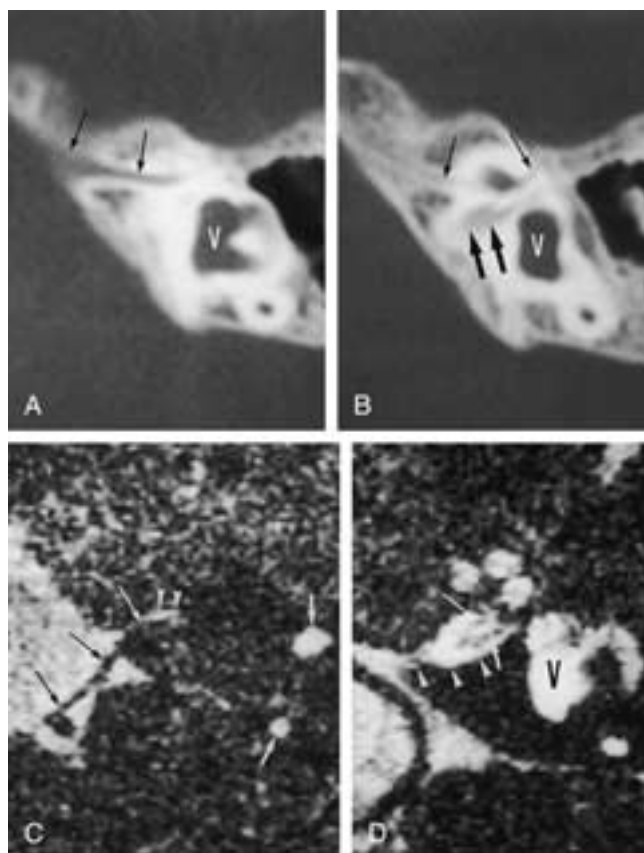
Facial nerve running in a separate canal parallel to the IAC. A and B, Axial CT image made above the left cochlea (A) and at the level of the upper part of the left cochlea and through the IAC (B). A, A separate canal for the facial nerve can be seen high and anteriorly in the left temporal bone (long black arrows). V, vestibule. B, The facial nerve canal can be followed posterior to the upper part of the cochlea (long black arrows). The IAC can now also be seen (large black arrows). V, vestibule. C and D, Axial 0.7 mm thick 3DFT-CISS images made at the level of the superior semicircular duct (C) and IAC (D). C, In the cerebellopontine angle, the facial nerve can be found in a high and anterior position (long black arrows) and continues its course in a separate facial nerve canal (long white arrow). Fluid in the labyrinthine segment of the facial nerve canal (white arrowheads) and fluid in the branches of the superior semicircular duct (small white arrows). D, The cochlear branch (long white arrow) and inferior vestibular branch (small white arrow) of the eighth nerve can be seen in the CSF-filled IAC (white arrowheads). V, Vestibule.
